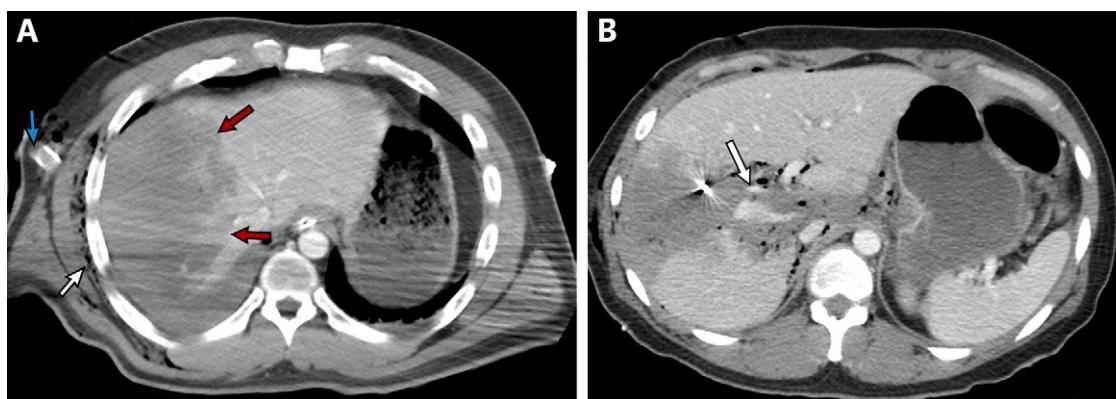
Grade V liver injuries according to the revised 2018 AAST-OIS. (A) Axial contrast-enhanced CT image in a 43-year-old man after a motor vehicle collision shows over 75% right lobe parenchymal disruption (red arrows). A partially visualized right-sided chest tube (blue arrow) and subcutaneous emphysema of the right chest wall (white arrow) are also noted. According to the AAST-OIS 2018 revision, the Couinaud segments are no longer used for quantifying parenchymal disruption. (B) Axial contrast-enhanced CT image in a 35-year-old woman after a gunshot wound shows a ballistic trajectory extending from the right hepatic margin to the hepatic hilum, transecting the inferior vena cava; contrast material extravasation (arrow), streak artifact from the metallic ballistic fragments, and air are noted along the bullet's trajectory. An axial cine clip of this patient is shown in Movie 10.
